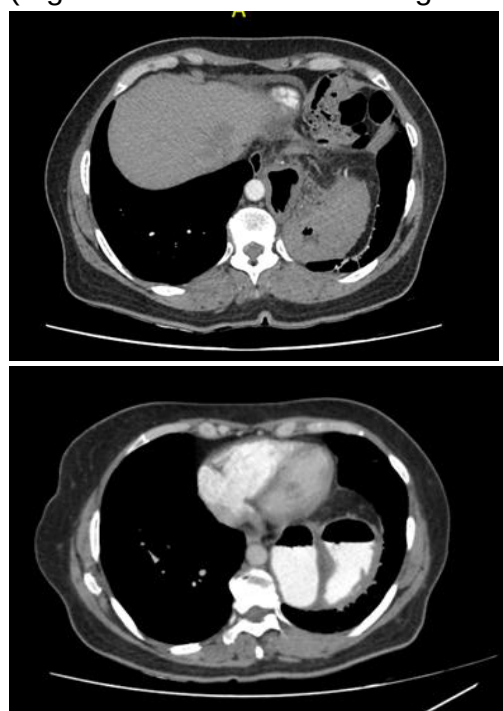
Contrast-enhanced and non-contrast chest computed tomography (CT), axial view, demonstrates the presence of abdominal organs within the thoracic cavity.
